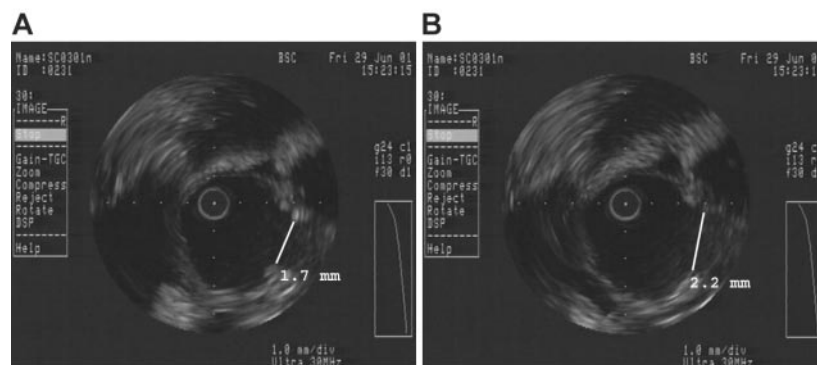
Intravascular ultrasound images of sutured anastomosis at (A) minimum opening width and (B) maximum opening width.
